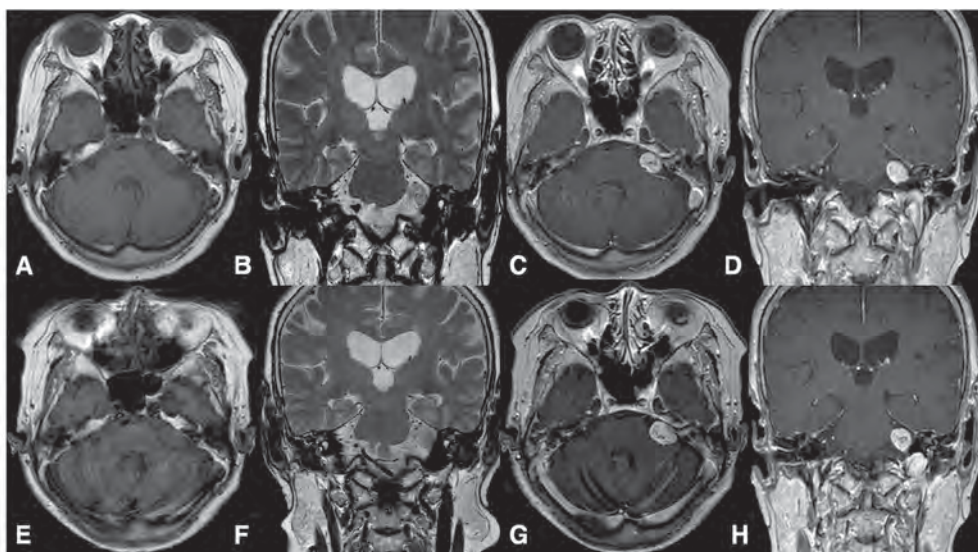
Brain MRI at the time of diagnosis revealed a $16 \times 11 \times 12$ mm sized tumor in the left cerebellopontine cistern, showing T1 hypointense, T2 heterogeneous intensity-irregular enhancement with extension to IAC, suggesting vestibular schwannoma. (A: T1 weighted axial, B: T2 weighted coronal, C & D: T1 weighted axial and coronal view with contrast enhancement) After 2.5 years of follow up, MRI revealed a slightly marginal increase in size which measured $18 \times 12 \times 12.5$ mm, but there was no cystic change or intratumoral hemorrhage. (E: T1 weighted axial, F: T2 weighted coronal, G & H: T1 weighted axial and coronal view with contrast enhancement)
